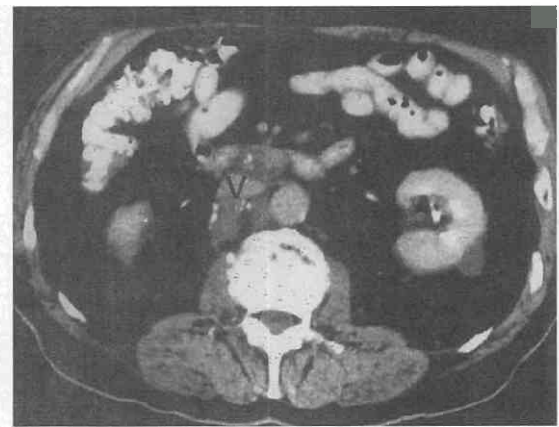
CT scan shows enlarged lymph nodes beside the aorta and behind the vena cava (V), resulting from histoplasmosis.
